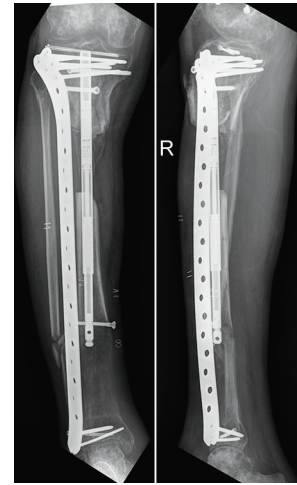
A/P and lateral radiographs demonstrating a successful 'recharge' of the Precise nail to gain cortical purchase of the most distal aspect of the transporting segment
